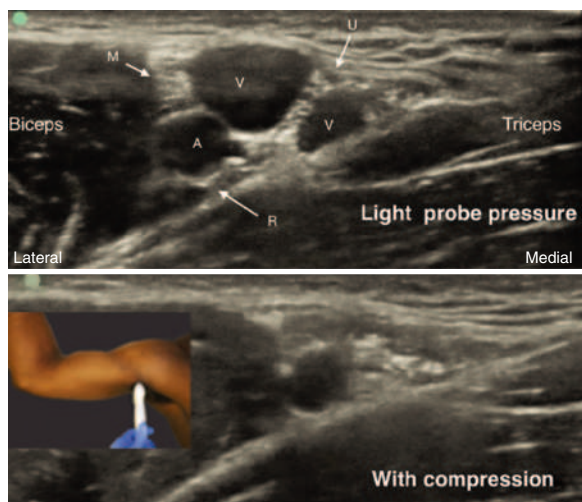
Ultrasound scanning of axillary brachial plexus and effect of probe pressure on visualization of axillary veins. The radial (R), median (M), and ulnar (U) nerves are seen close to the axillary artery (A) and veins (V). To identify all the vascular structures and avoid intravascular injection, light pressure scanning is used to visualize veins that can be easily compressed with probe pressure during needle advancement.
